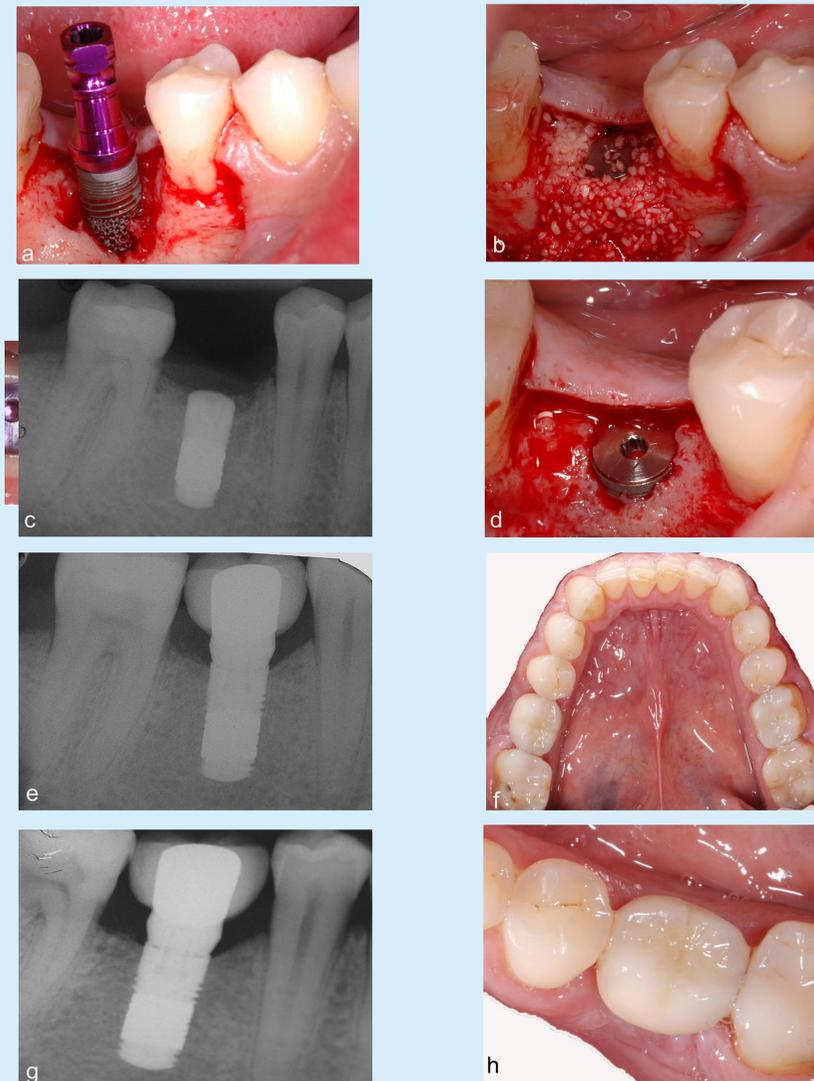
Clinical and radiographic views of a male patient who reported smoking 70 cigarettes/week. A TM dental implant was used to replace the mandibular right first molar. The implant was placed with simultaneous augmentation with an allograft(a, b, c). Figure (d) shows the implant at re-entry. A cement-retained final restoration was placed at 6 months(e, f). The implant was stable and without complications at the 1 year follow up appointment. The average change in marginal bone level from surgery to 1 year was 0.24mm (g, h). Case courtesy of Dr Sergio Spinato, Italy.
